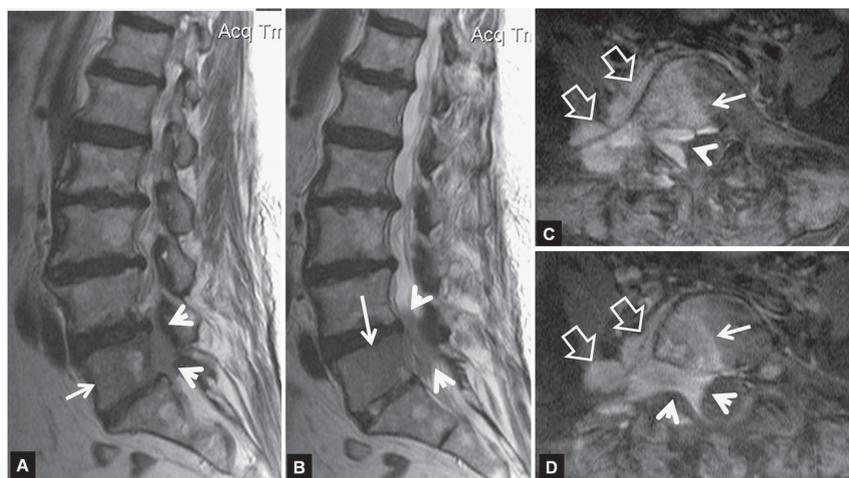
MR imaging study including sagittal T2w (A, B) and contrast-enhanced fat-suppressed T1w (C, D) pulse sequences of a 78-year-old female patient with a final diagnosis of non-Hodgkin lymphoma. There is bone marrow involvement (arrows in A-D), epidural space involvement (arrowheads), and paraspinal small lymph node involvement (open arrows in C, D).
